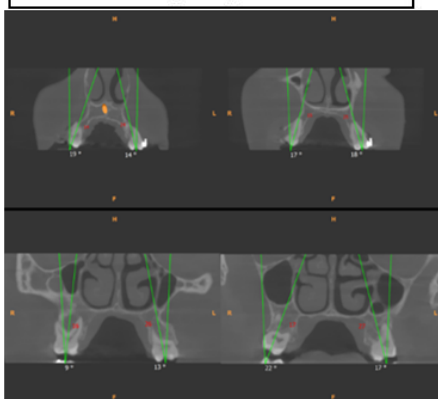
Pre-treatment CBCT for Buccolingual inclination of maxillary posteriors (Inclination measured on coronal section using an angle formed between a line passing through the long axis of the tooth to a vertical line parallel to the mid-sagittal plane)
